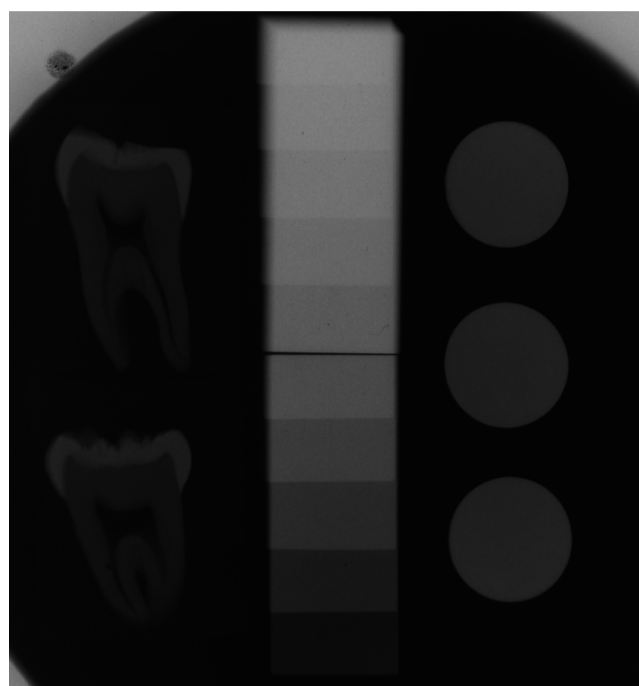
Radiograph of the Linkmax luting material taken together with molar slices and aluminum step wedges.
